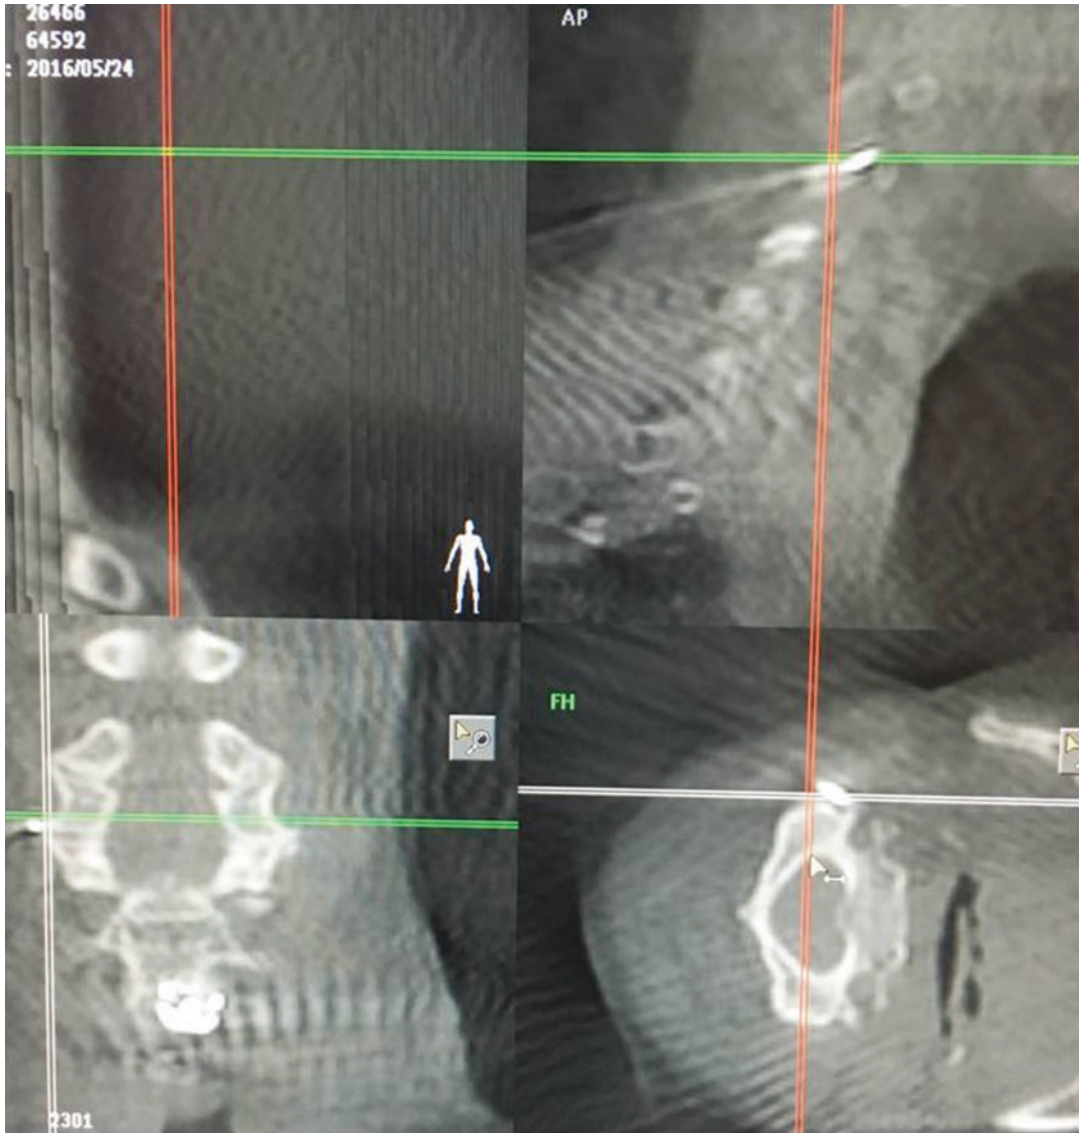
Combining fluoroscopic guidance and cone beam CT (3D acquisition) augments safety and efficacy of the technique by providing anatomical details of needle tip position
